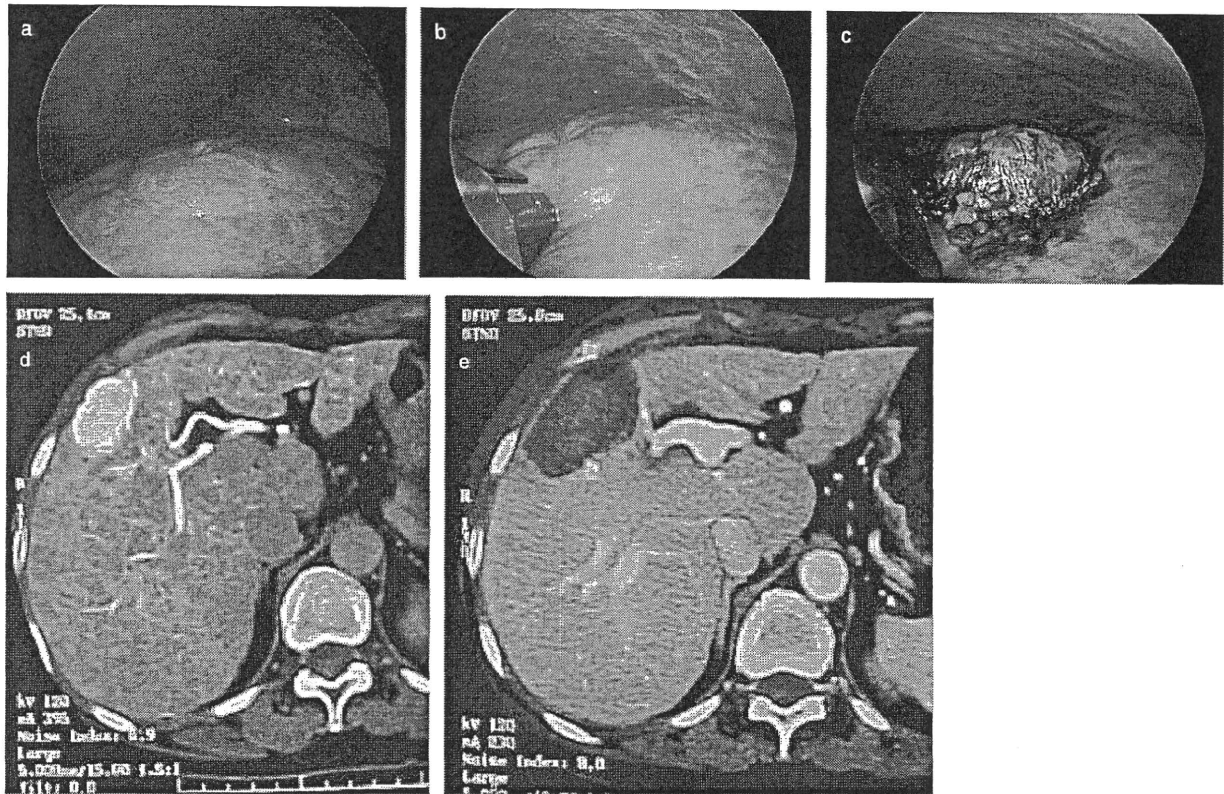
Hepatocellular carcinoma (HCC) nodule protruding from the liver surface is treated by laparoscopic radiofrequency ablation (RFA) under ultrasound guiding. (a) HCC nodule is directly observed under laparoscopy. (b) Under laparoscopic ultrasound guiding, RFA electrode is introduced to accurate position of the nodule, avoiding damage to diaphragm and intrahepatic vessels. (c) The entire HCC nodule was completely ablated by RFA. (d) Computed tomography (CT) scan before the treatment revealed hypervascular nodule with 2.6 cm in diameter at the surface of the liver. (e) After laparoscopic RFA, complete necrosis was confirmed by CT scan.
